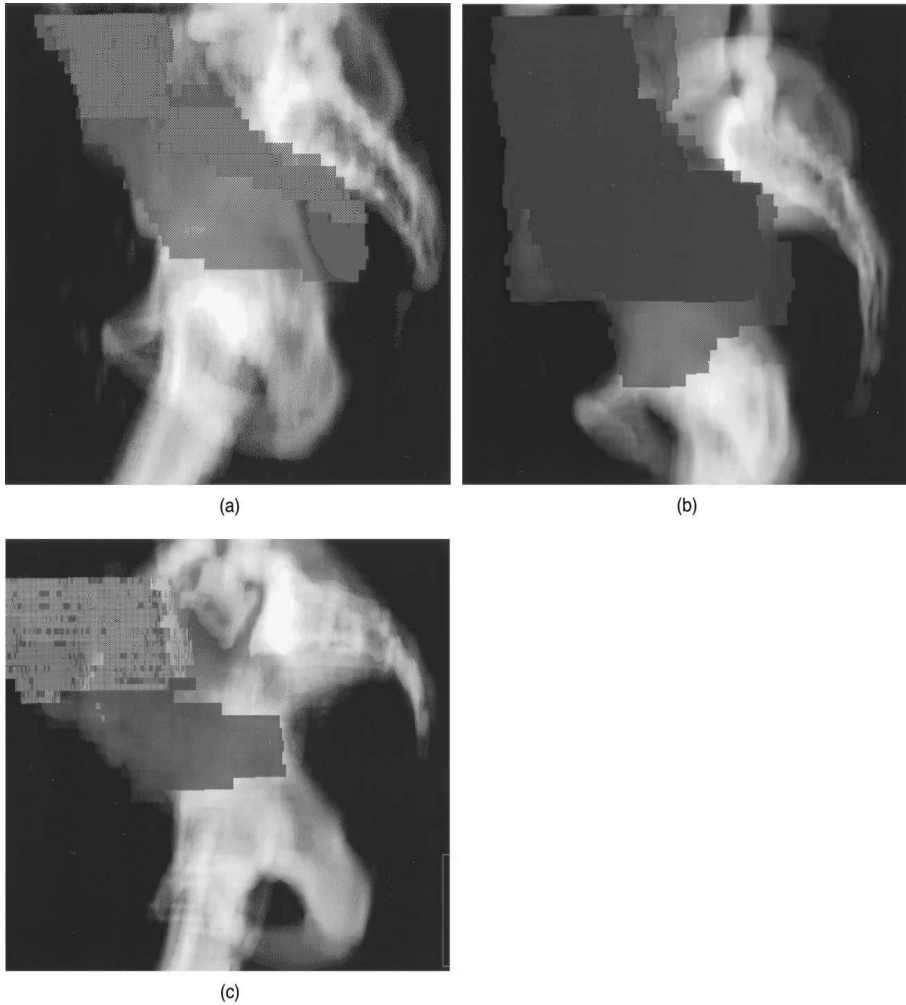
Digitally reconstructed radiographs showing the maximum and minimum position of the small bowel observed during a course of adjuvant pelvic RT. (a) A patient with an abdominoperineal resection, with the maximum position shown in green, the minimum in red, and overlap shown as a combination of the two colors. (b) A patient with a low anterior resection, with the maximum position shown in blue, the minimum in red, and the overlap in purple. (c) A patient receiving preoperative treatment, with the maximum shown in blue, the minimum in yellow, and overlap in tan.
